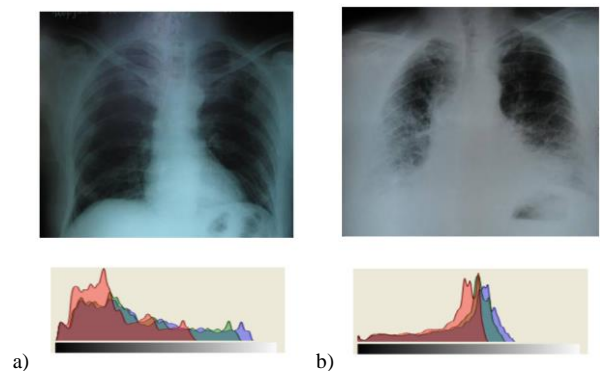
Examples of X-ray plates coloring resulting of aging of the plate material.
